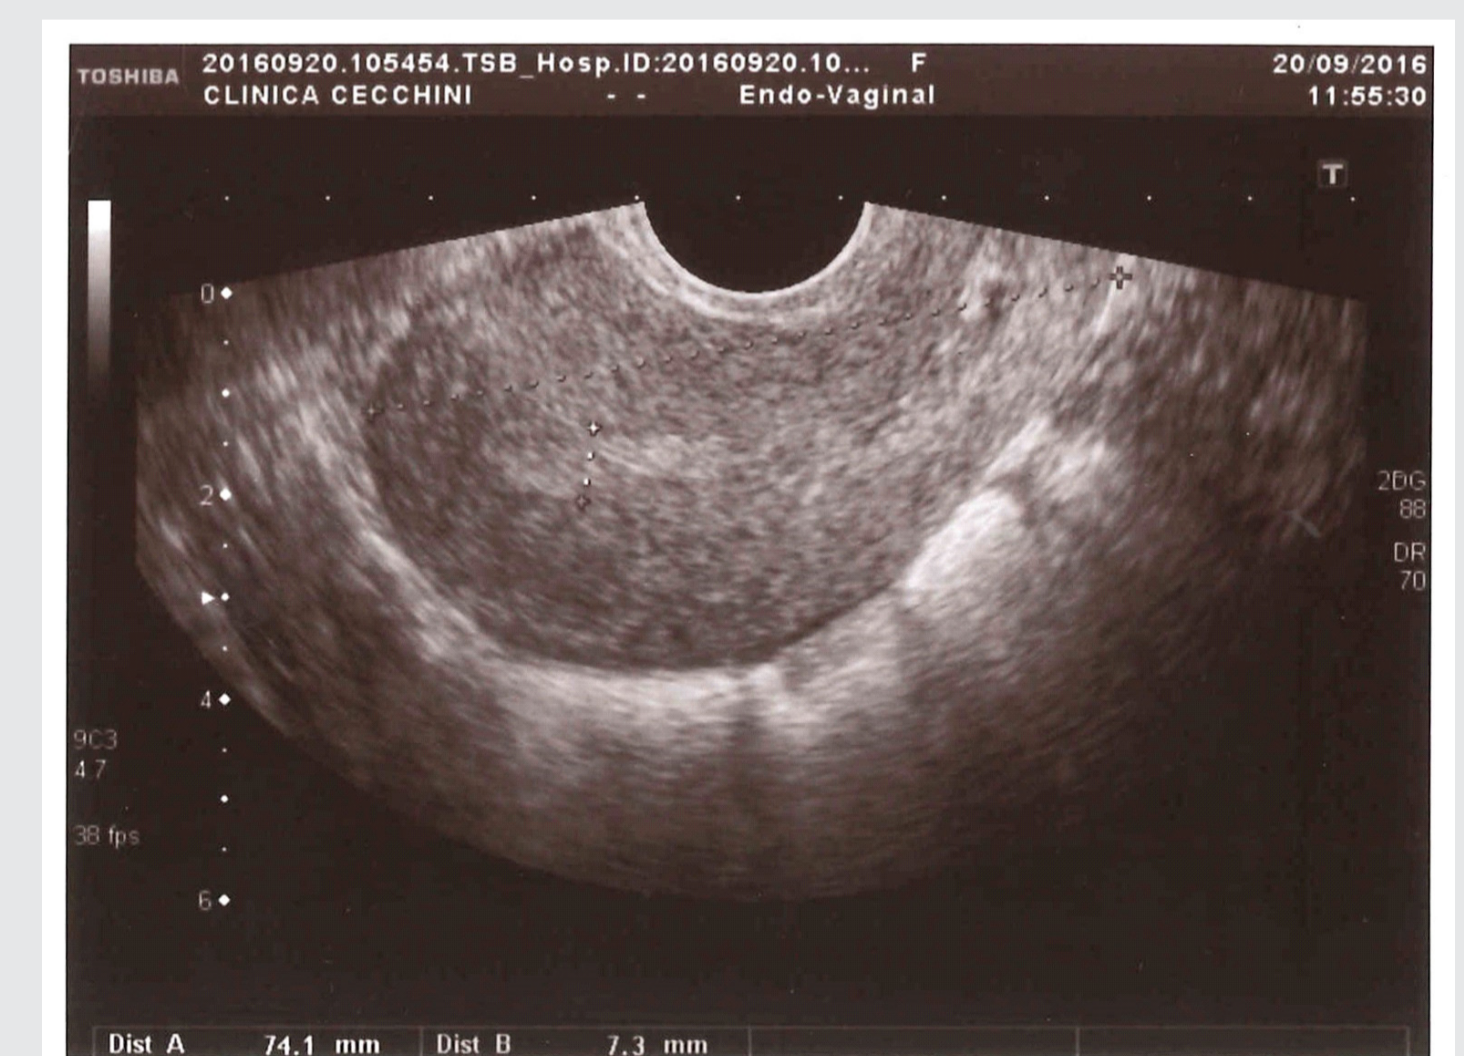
Final ultrasound assessment. 7.3 mm uterine mass
